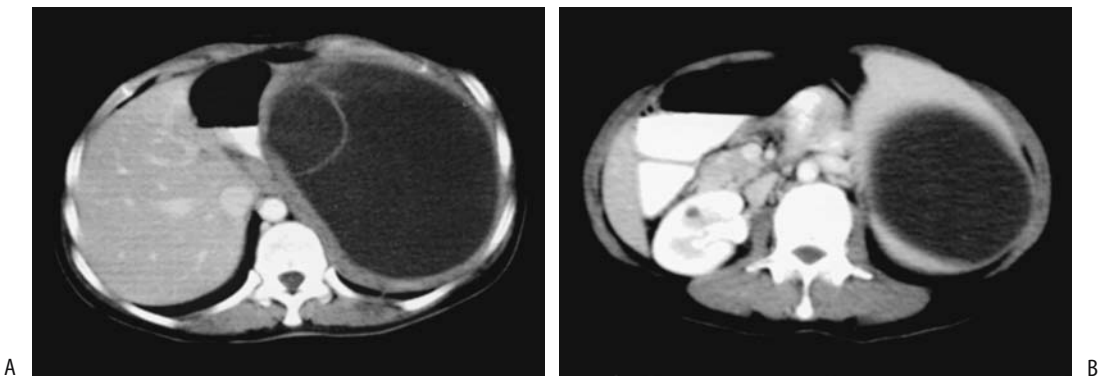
Isolated splenic hydatid disease. Contrast-enhanced CT through upper (A) and lower (B) poles reveals a large cystic nonenhancing structure. A daughter cyst is evident in A. (Source: Polat P, Kantarci M, Alper F, Suma S, Koruyucu MB, Okur A. Hydatid disease from head to toe. *RadioGraphics* 2003;23:475–494, with permission from the Radiological Society of North America.)
